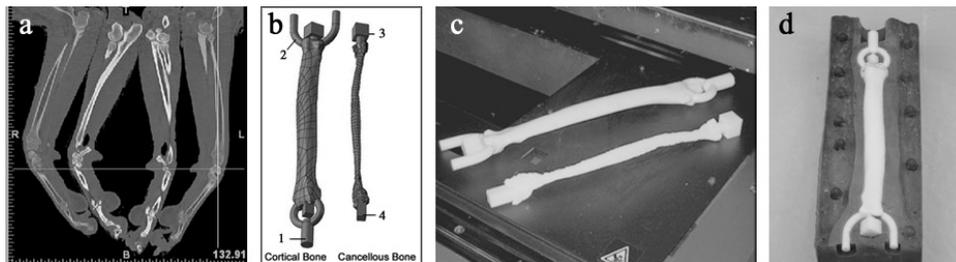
Images showing: a screenshot of CT data (a); images of the cortical and cancellous bone 3-D models with the filling sprue (1), air vents (2) and 3-D geometric locating features (3,4) (b); finished plastic models of the cortical and cancellous models (c); and polyurethane rubber mold (d).
